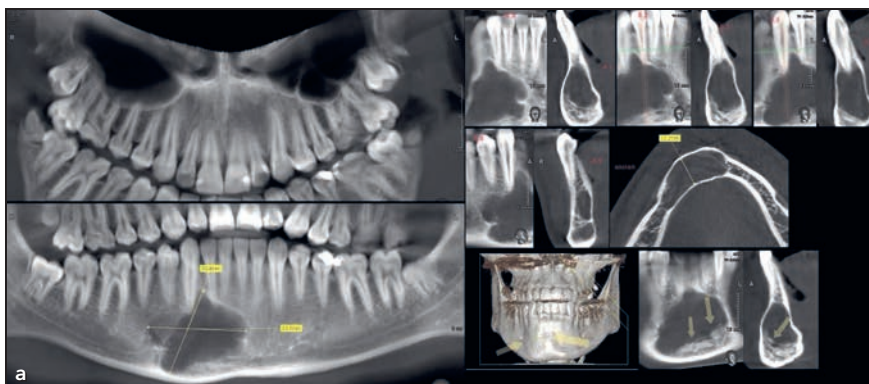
(a) CBCT scan of the right parasymphysis area of the mandible, showing the sizable traumatic mandibular cyst. The arrows indicate necrotic deposits in the bottom of cyst. (b) Preoperative intraoral situation. No teeth or mucosa changes were seen in the projection of the cyst.
